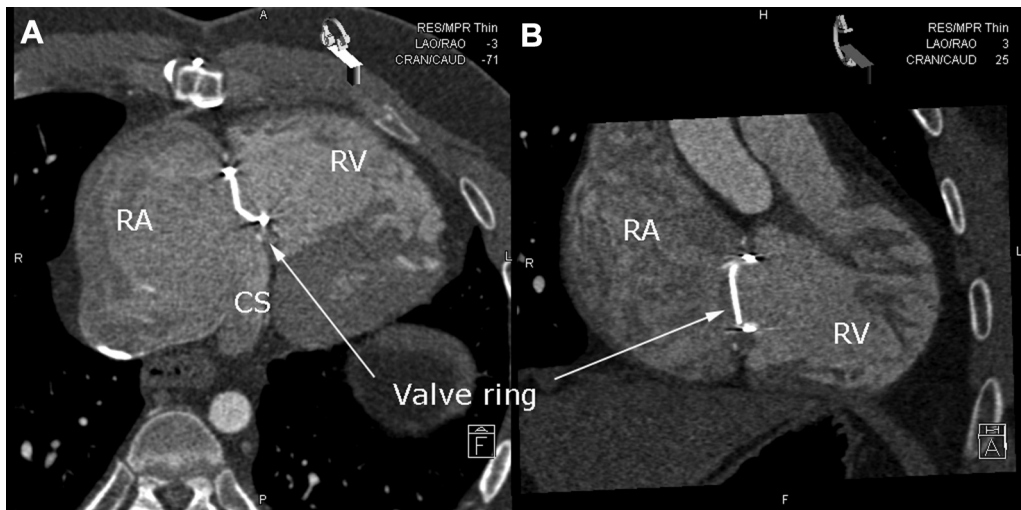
Multislice contrast-enhanced computed tomography scan. A: The coronary sinus drains into the right atrium under the ring of the mechanical valve (white arrow). B: The right oblique view of the computed tomography scan revealed that the ring of the mechanical valve is located on the true atrioventricular annulus. CS = coronary sinus; RA = right atrium; RV = right ventricle.
